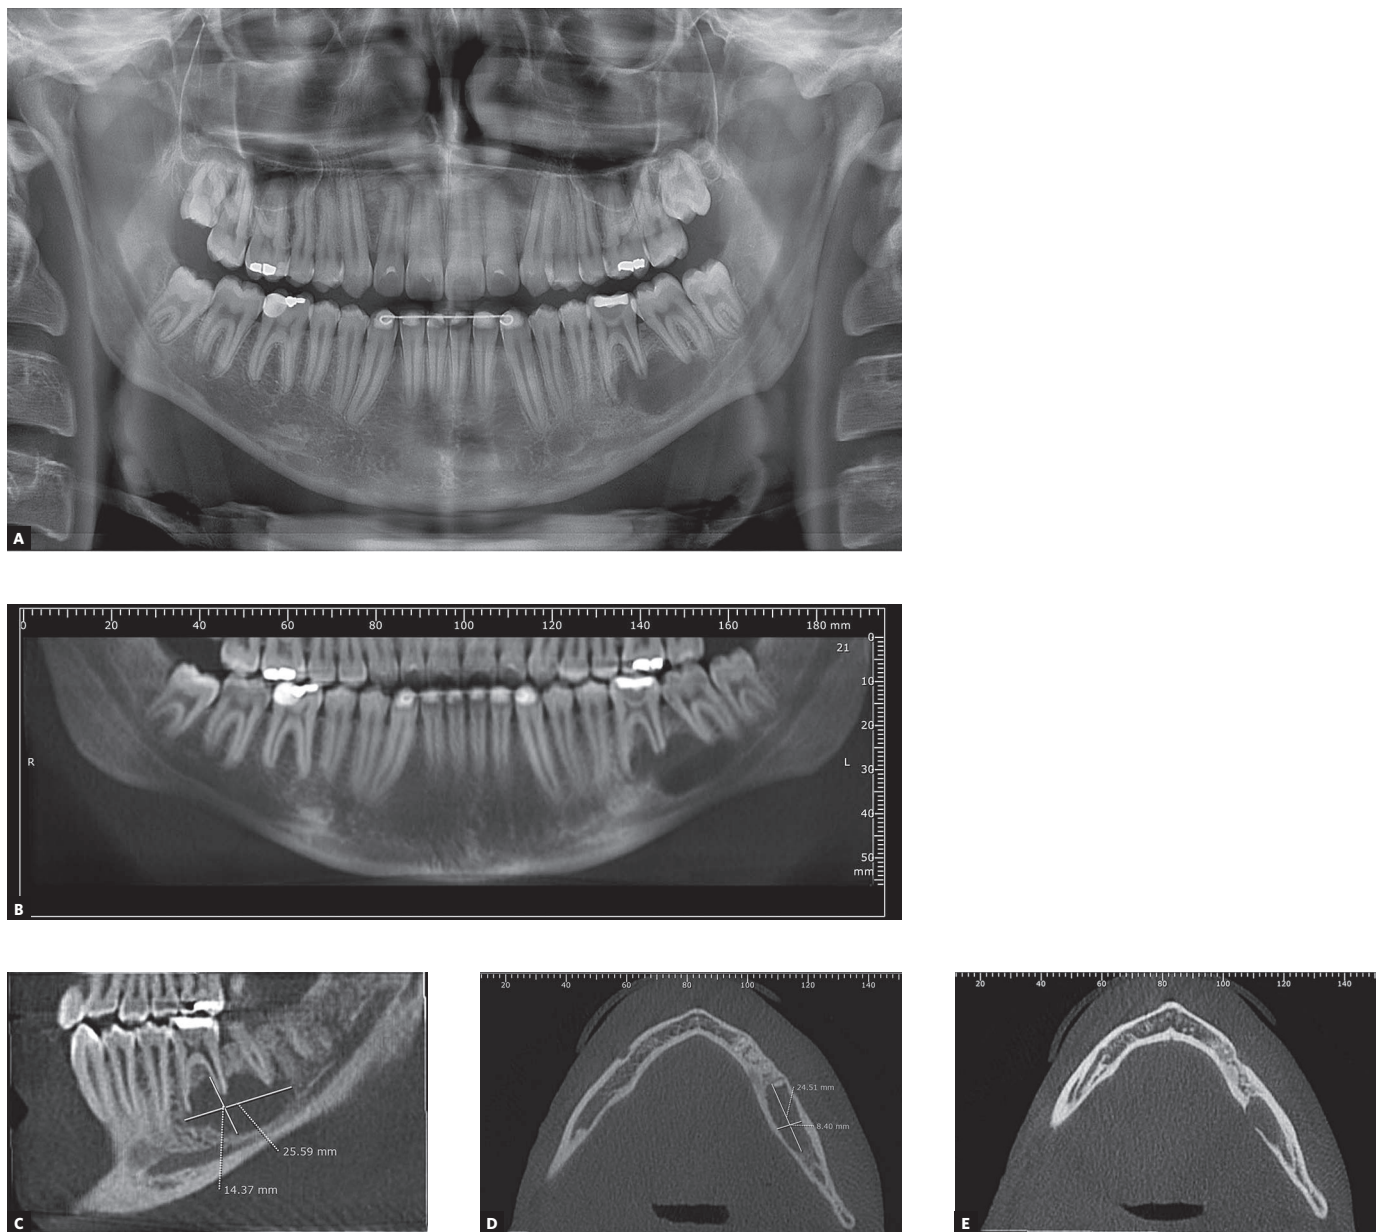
(A) Panoramic radiograph (August/2015). (B) CBCT, coronal-panoramic image (November/2015). (C and D) CBCT, sagittal image and lesion dimensions (mm). (E) CBCT, axial image showing external lingual cortical bone disruption.
